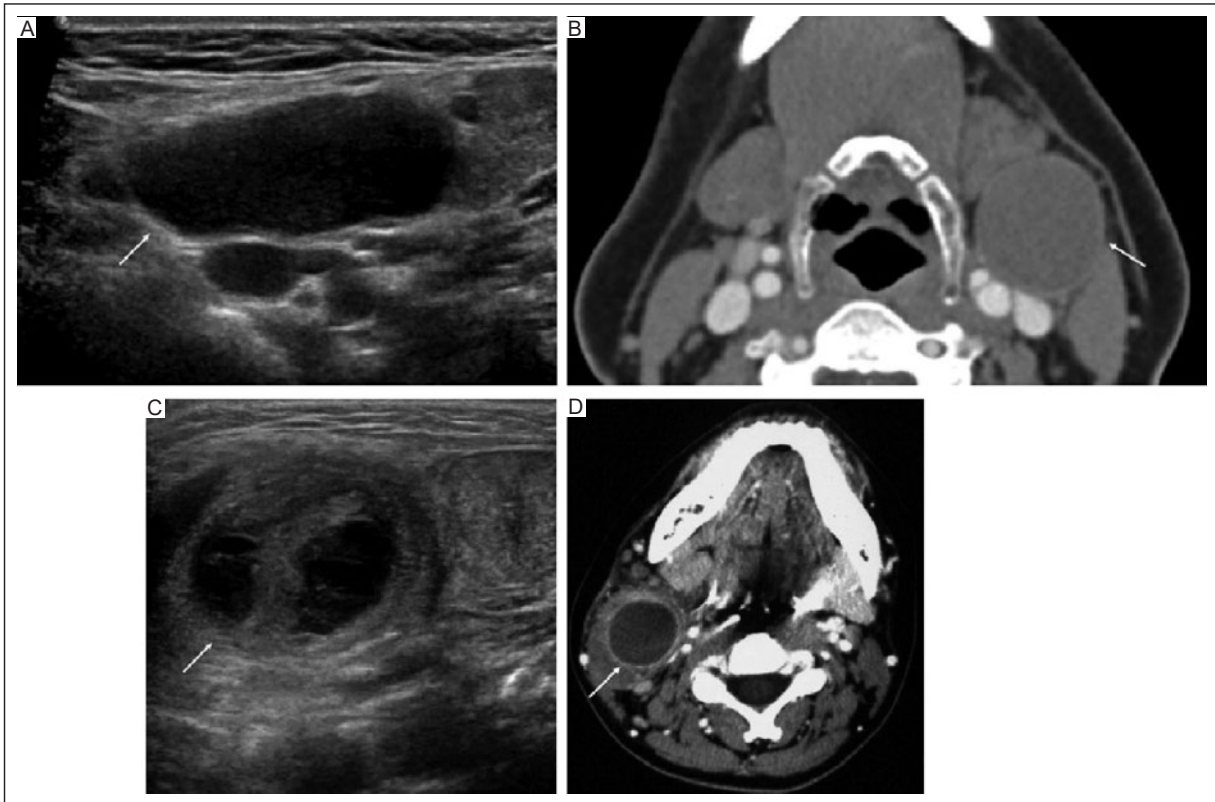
Second branchial cleft cyst. A: ultrasound, and B: contrast-enhanced CT of the neck show a thin-walled well-circumscribed non-enhancing hypoechoic/hypodense lesion between the left submandibular gland and sternocleidomastoid muscle, anterior/superficial to the carotid sheath, consistent with Bailey type II second branchial cleft cyst (arrows). C: ultrasound and D: contrast-enhanced CT of the neck show a more complex thick-walled hypoechoic/hypodense lesion deep to the right sternocleidomastoid muscle with internal septations, enhancement of the walls and peripheral fatty stranding, consistent with an infected Bailey type II second branchial cleft cyst (arrows).
